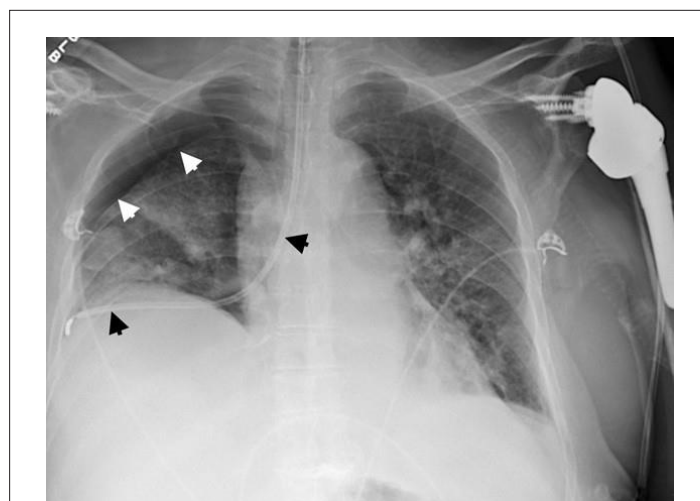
Patient's chest x-ray immediately after insertion of nasogastric tubec
